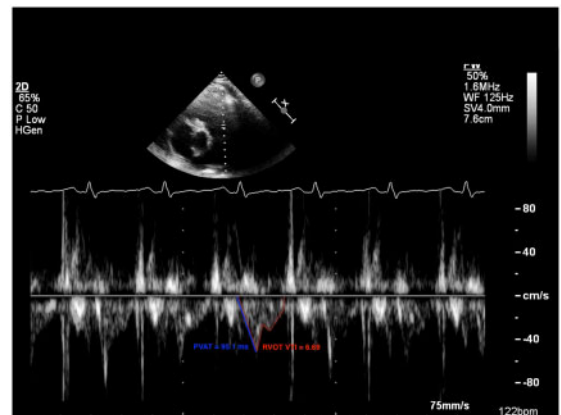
Bedside echocardiogram with parasternal short-axis view and pulsed wave Doppler of the right ventricular outflow tract. Right ventricular outflow tract velocity time integral was calculated at 6.69 cm. Pulmonary velocity acceleration time measures 95.1 ms without signal notching, suggestive of pulmonary hypertension (normal > 130 ms).
